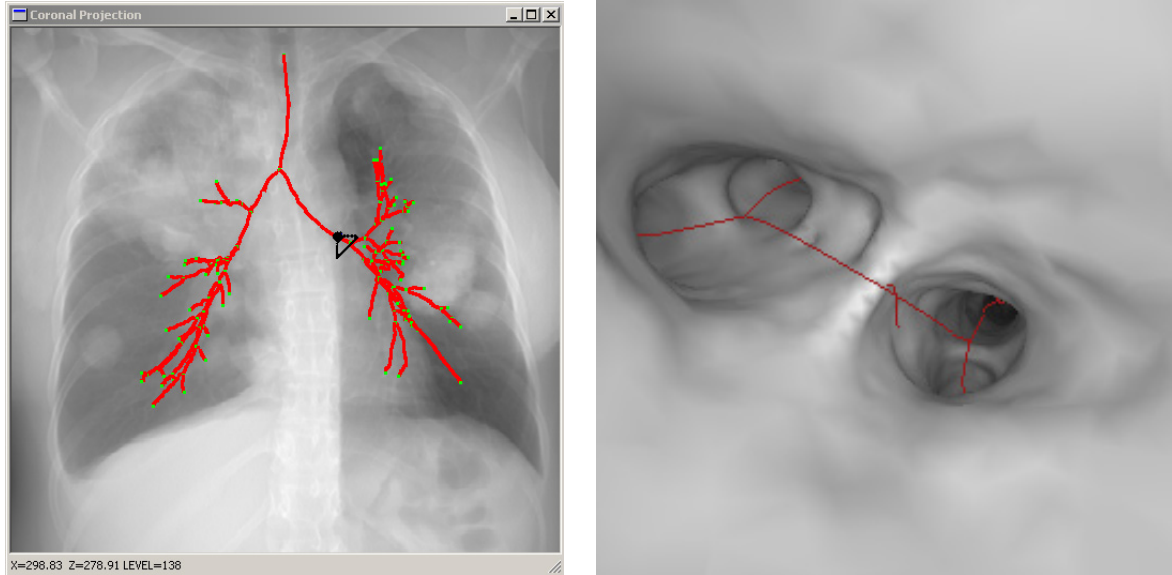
3D position and direction of location E of the example bronchial tree. The left image, a coronal maximum-intensity projection of 3D CT data set and associated path file [lines], gives the location and viewing direction of the user in the tree, as identified by a large dot attached to a viewing triangle. The right image is the CT-based endoluminal rendering rendering at the location.
